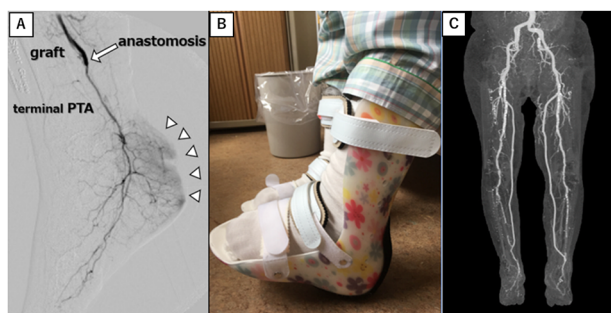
Complete angiography showed a well-visualized wound blush in the right heel (A: arrowheads). Heel covering devices provide heel pressure relief by creating a space between the heel and the devices, and the devices can reduce the incidence of pressure injuries (B). Multidetector row computed tomography showed that the bilateral bypass grafts were both patent, and no stenosis occurred (C).
